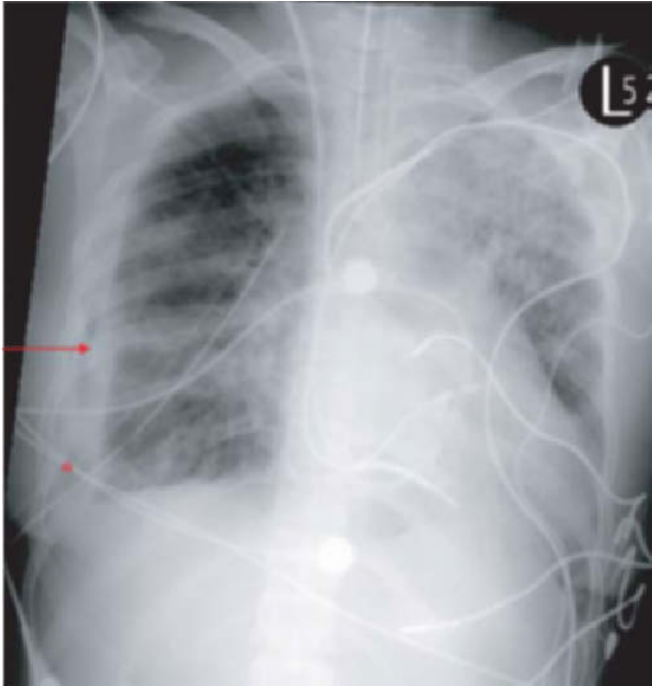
“Trapped” lung, complication of malignant pleural effusion. This figure shows a PA chest radiograph performed in an individual with diffuse right pleural malignancy and effusion status post insertion of a “standard” thoracostomy tube. Note the extensive visceral pleural thickening (arrow) and small, lateral pneumothorax *ex vacuo* (star). This patient is not a candidate for chemical pleurodesis, and can either be managed with surgical decortication, or with exchange for a tunneled pleural catheter to facilitate home drainage of the effusion. The choice of surgery versus Pleurx® is made on the basis of performance status and life expectancy.
